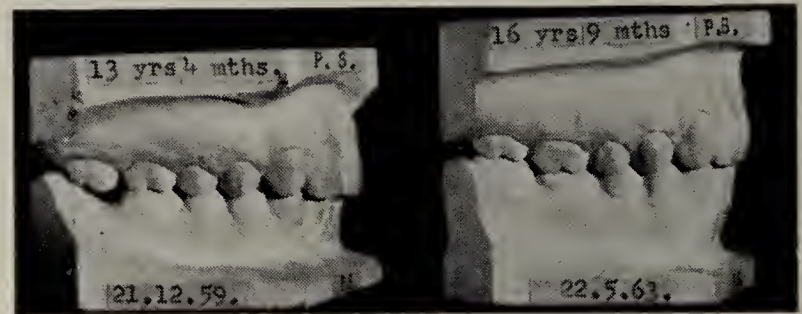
Extraction of $\overline{7|7}$ at 12 years. Models before and after extraction of over-erupted $\overline{7|}$. Radiographs to show initial and final position of $\overline{8|}$ and $\overline{8|}$.
